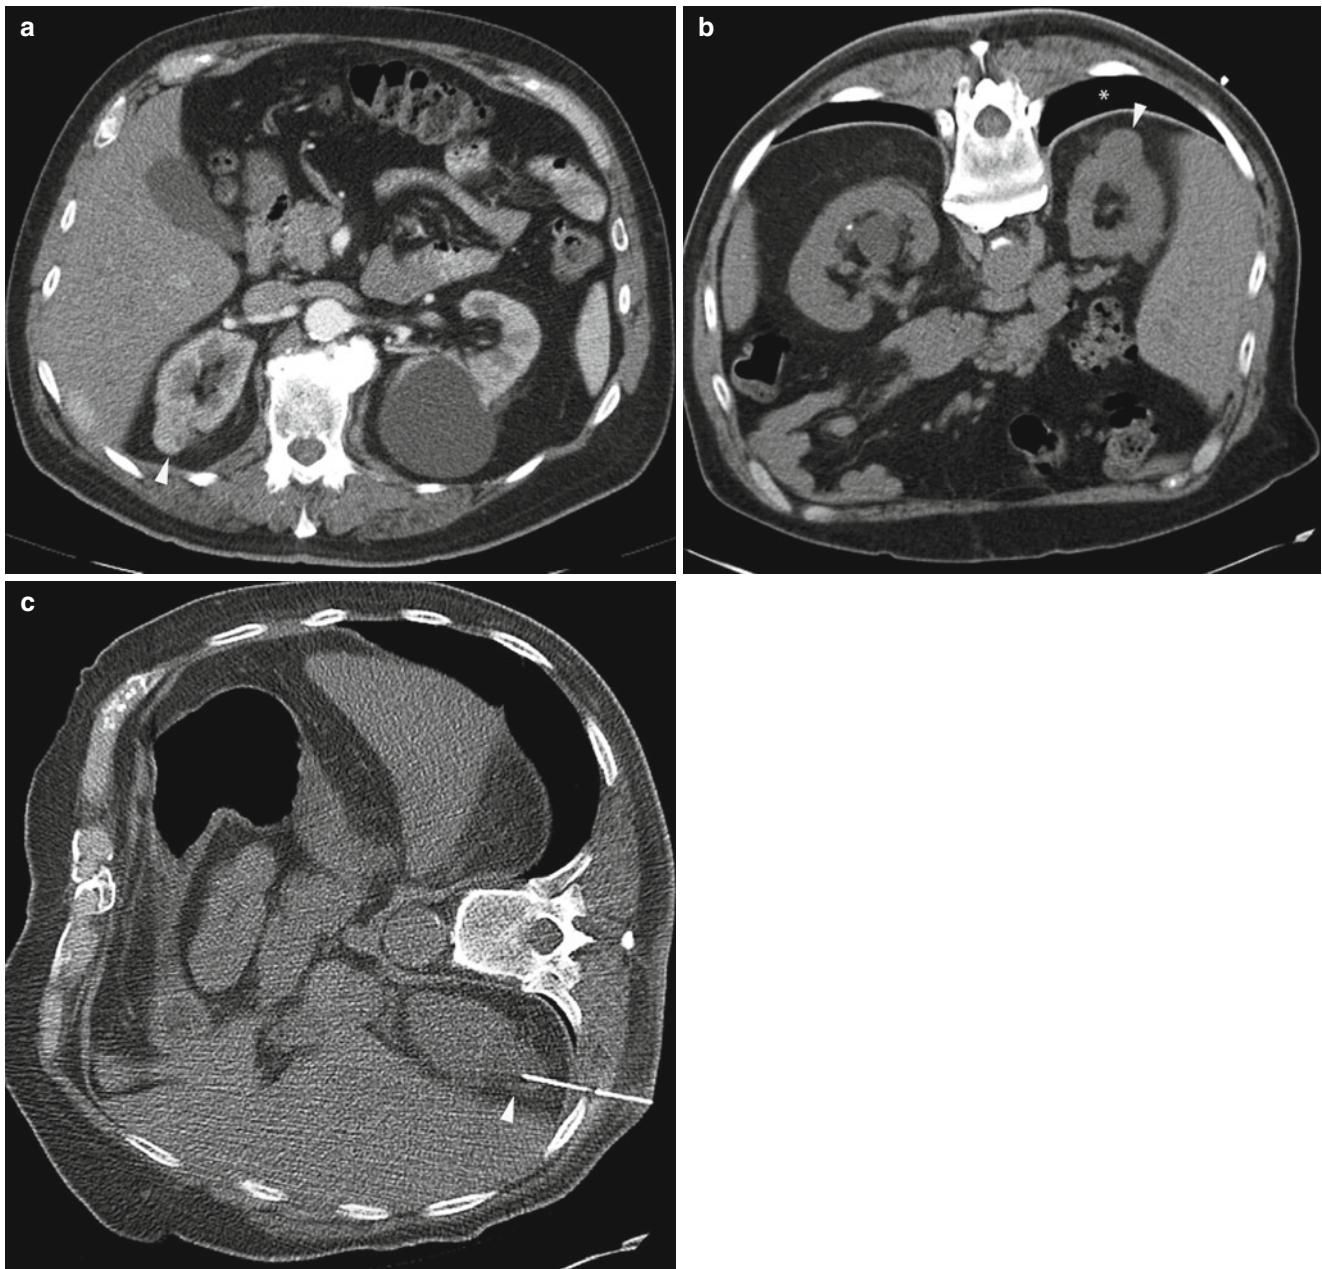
A 78-year-old man was referred for biopsy of a right kidney mass for consideration of percutaneous thermal ablation. Axial CT image of the abdomen (a) shows a solid enhancing mass (*arrowhead*) in the upper pole of the right kidney. Axial image of the abdomen in prone position (b) shows intervening lung (*asterisk*). When patient was
